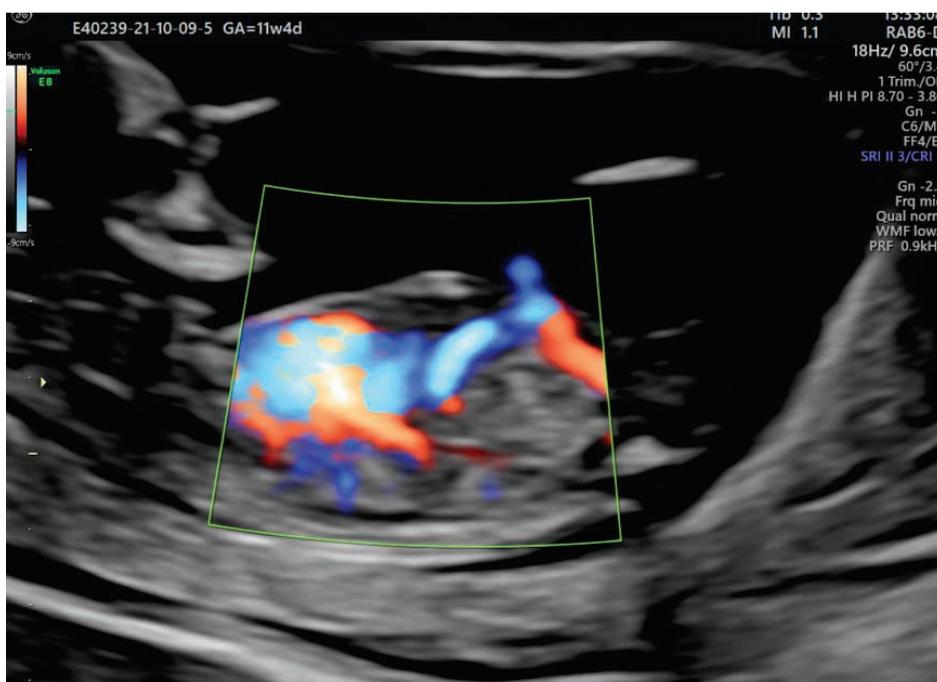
Absence of ductus venosus in color Doppler imaging (personal collection of Roxana Bohiltea)
